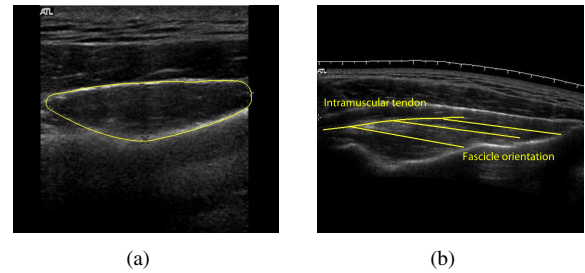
In-vivo* ultrasonographic assessment for the supraspinatus: (a) Segmented cross-sectional area of the transverse image. (b) Sampled fascicles and intramuscular tendon of the longitudinal image.
